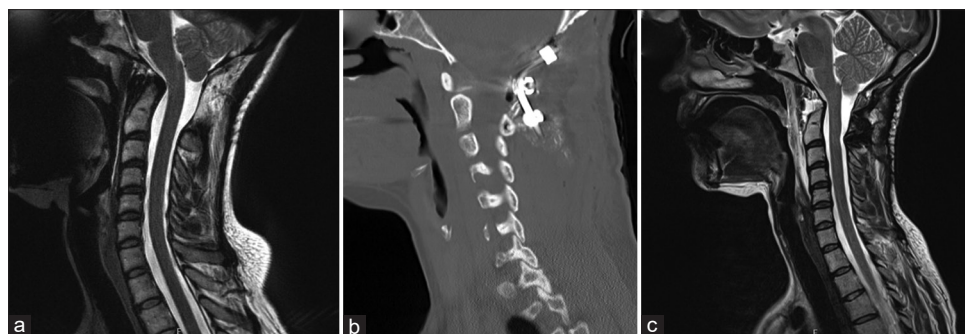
Case 4 imaging – Odontoidectomy (a) Preoperative T2-weighted sagittal cervical MRI demonstrating restricted CSF flow posterior to the cerebellum, pannus formation posterior to the dens, a slightly retroflexed odontoid process, and slight kinking of the anterior brainstem. (b) Postoperative sagittal cervical CT 1-day after OC2 fusion demonstrating expected postsurgical changes. (c) Postoperative T2-weighted sagittal cervical MRI 10 months after O-C2 fusion and 1-day after odontoidectomy showing expected postsurgical changes. MRI: Magnetic resonance imaging, CSF: Cerebrospinal fluid, CT: Computed tomography
